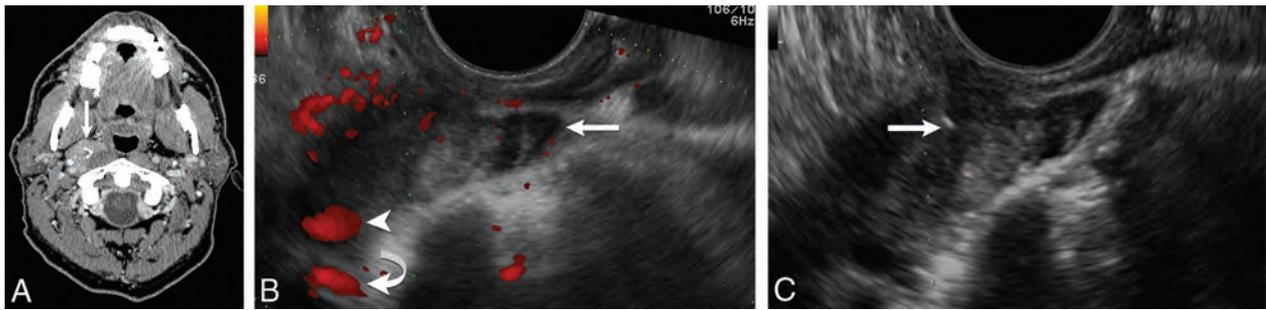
True-positive cytology. A 65-year-old man with a history of papillary thyroid cancer and a right retropharyngeal mass. *A*, Axial contrast-enhanced CT scan shows an enlarged right retropharyngeal node (*arrow*) with internal calcification. *B*, Transverse power Doppler sonography shows the lesion (*arrow*) and its relationship to the internal carotid artery (*arrowhead*) and internal jugular vein (*curved arrow*). *C*, Transverse sonography during biopsy of the mass documents placement of needle tip (*white arrow*) within the lesion before and during aspiration. Cytology revealed metastatic papillary thyroid cancer.
